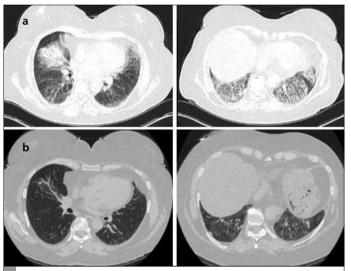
a, b. High-resolution CT (HRCT) findings of the lungs before (a) and after (b) the treatment
